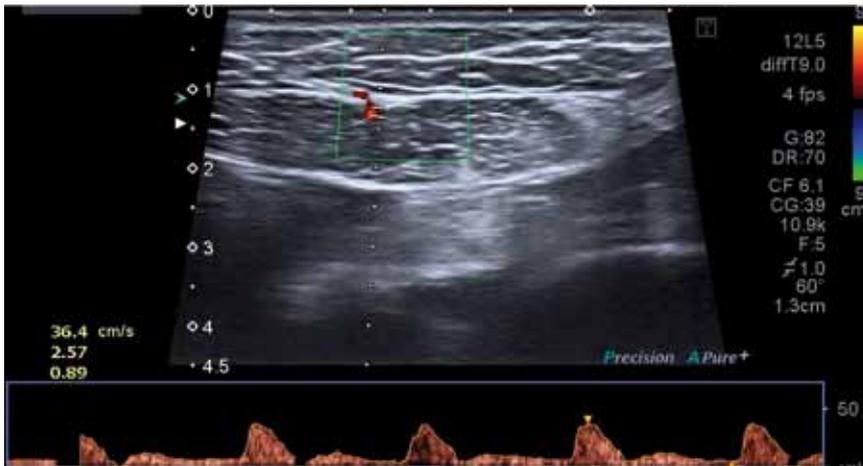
Ultrasound examination of intraoperatively perforated vessels
